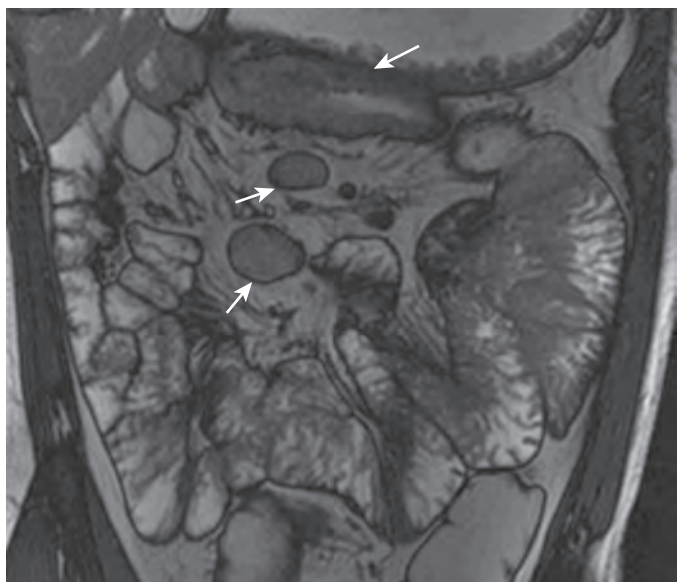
T-cell lymphoma complicating celiac disease. This coronal MRI scan shows mural thickening of the jejunum (long arrow) and enlarged lymph nodes (arrows) in the adjacent mesentery. (Courtesy Gabriele Masselli, MD, Rome, Italy.)
